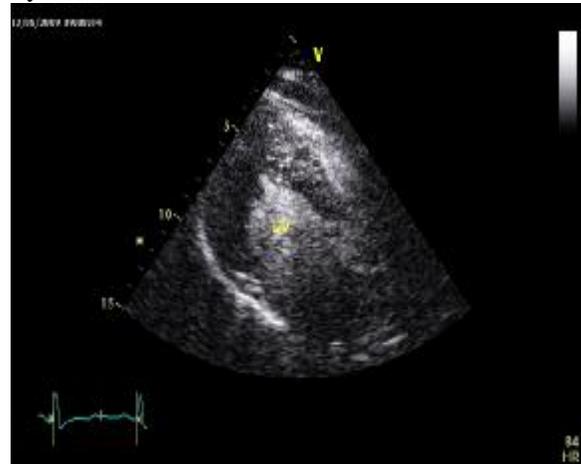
Contrast echocardiography: apical two-chamber view show and systole (right panel) along with severe hypertrophy of apical LV: left ventricle.
